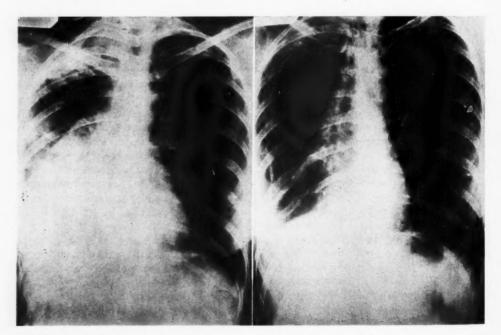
Case 3. A number of dense infiltrations in the right apex. Right inferior lobe of almost uniform density, shadow stopping very abruptly at interlobular fissure. (Roentgenogram made Jan. 1, 1024) 1934.)
